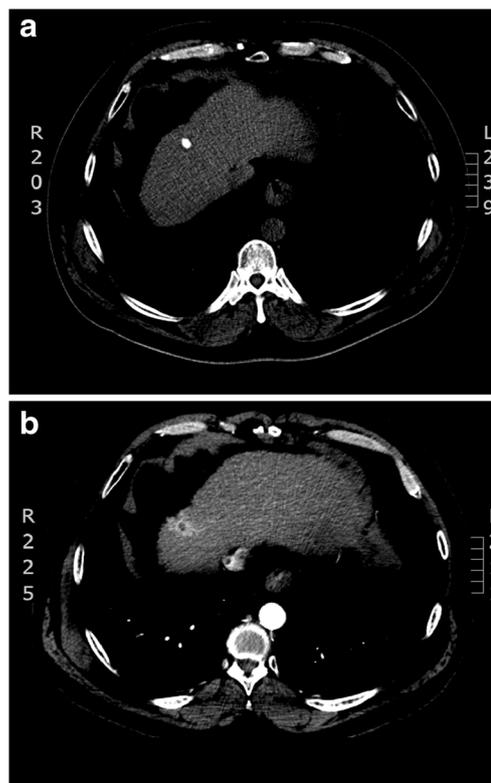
a Follow up CT scan 2 years later with retained lipiodol and no evidence of recurrent tumor. b Three months later, small hypodense focus superior to retained lipiodol was discovered, possibly representing necrosis, and new arterial enhancement without definitive washout seen adjacent
